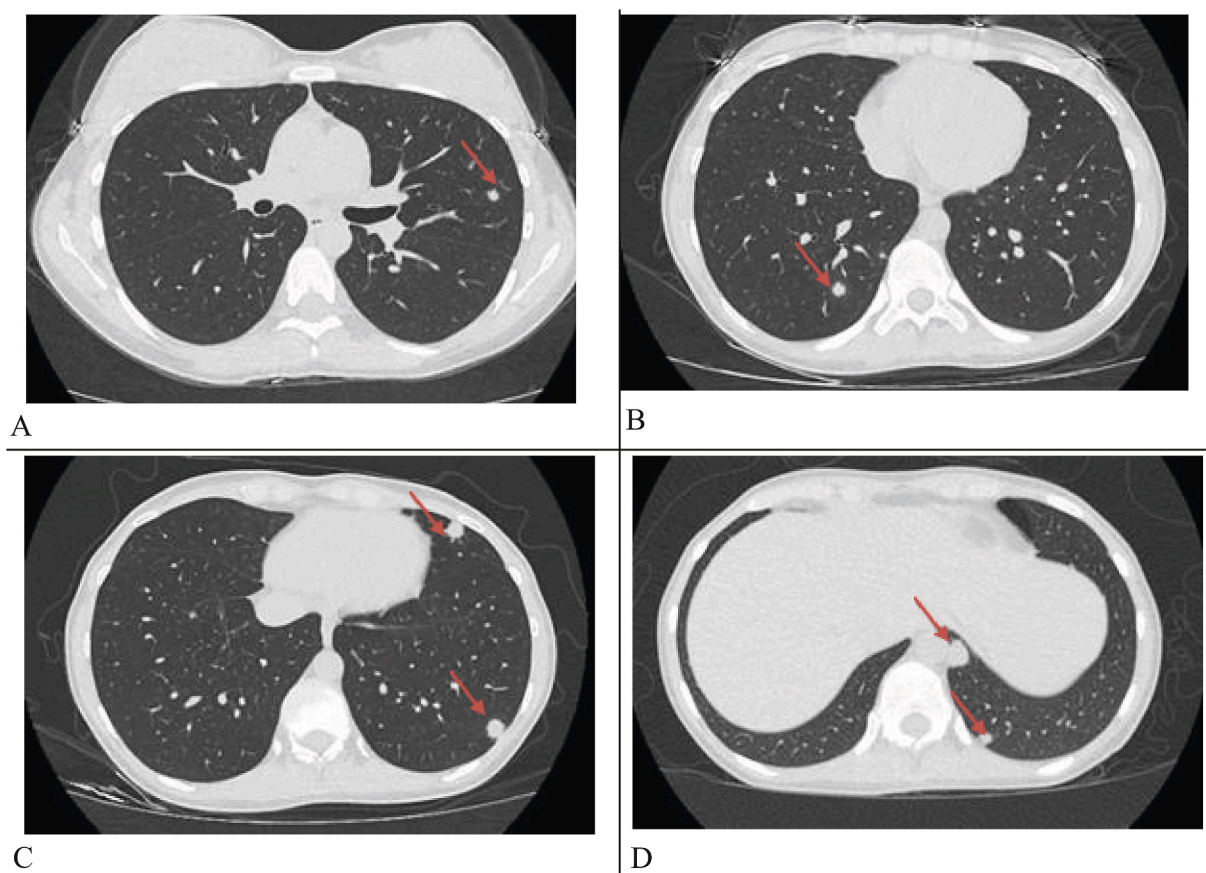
Representative CT images showing multiple, bilateral, round, well-circumscribed, non-calcified nodules. Specifically, there was a 6-mm nodule within the upper left lobe (A), a pleural-based 9-mm nodules in the lingula (C), a 13-mm nodule in the left lower lobe overlying the aorta (D), and a 10-mm nodule in the right lower lobe (B).
